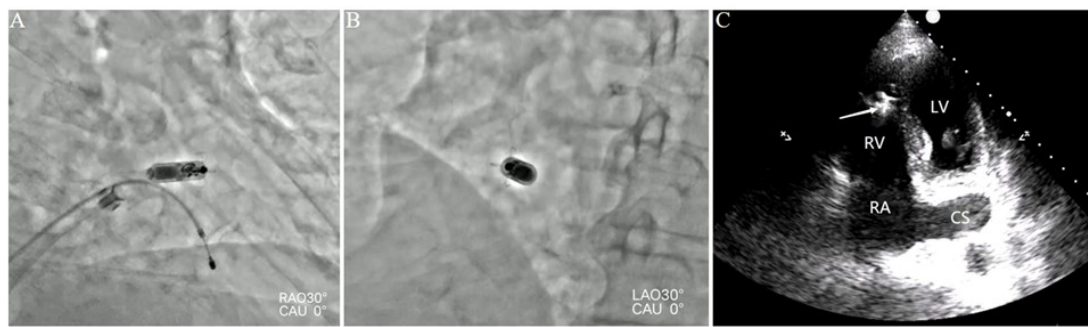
X-ray radiography showing the placement of a leadless pacemaker and transcatheter pacing system in the right ventricle. A: Right anterior oblique view at 30° with caudal 0°. B: Left anterior oblique view at 30° with caudal 0°. C: The LP is fixed in the septum of the RV, as confirmed by echocardiography (arrow). Abbreviations: LP: leadless pacemaker, RV: right ventricle, LV: left ventricle, RA: right atrium, LA: left atrium.
